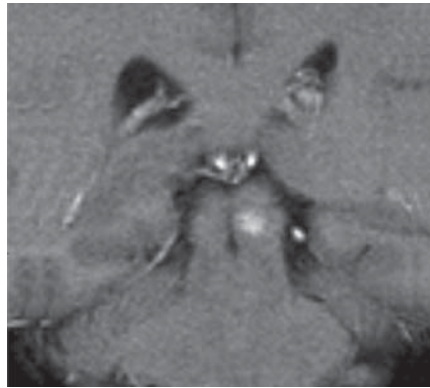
MRI of the brain on 25.01.2005, T1 GRE coronal (TR 297, TE 10). Hyperintense lesion in the left colliculus inferior caused by methhemoglobin.
